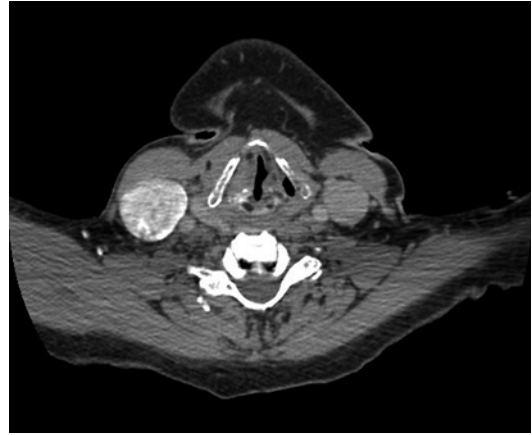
Computed tomography of left vocal fold paralysis. There is atrophy of the vocal fold with asymmetric prominence of the left pyriform sinus and laryngeal ventricle, suggesting chronic denervation
